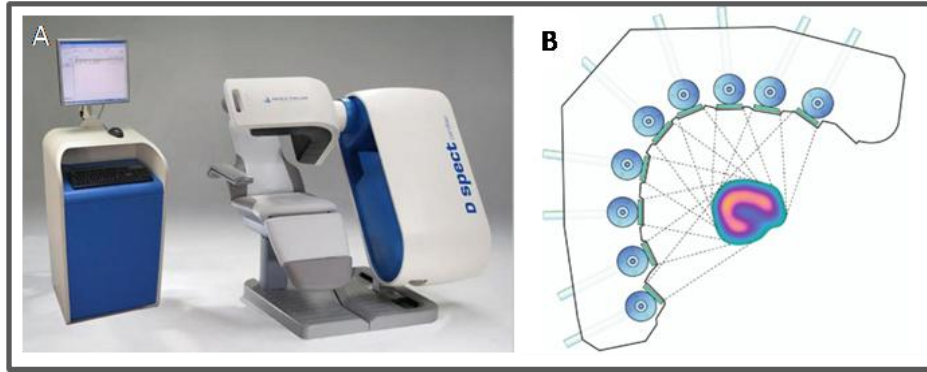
A. D-SPECT system²⁵. B. Axial view of the D-SPECT system acquiring data from the heart. The detectors are scanning the heart, focusing on the region of interest (ROI)²⁶.
